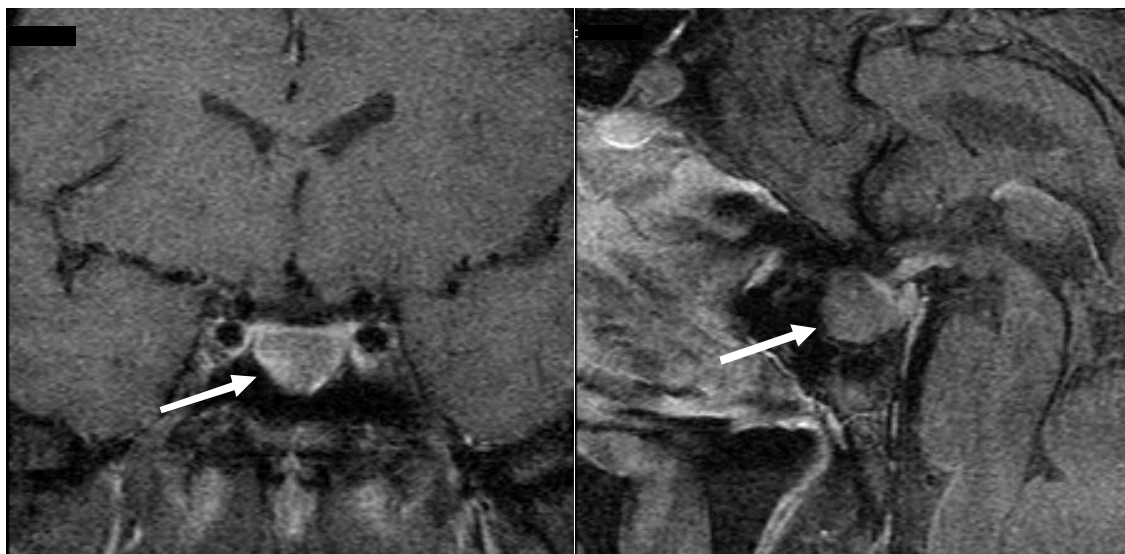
MRI brain sagittal and coronal images demonstrating wide sella with enlarged pituitary (white arrows).
